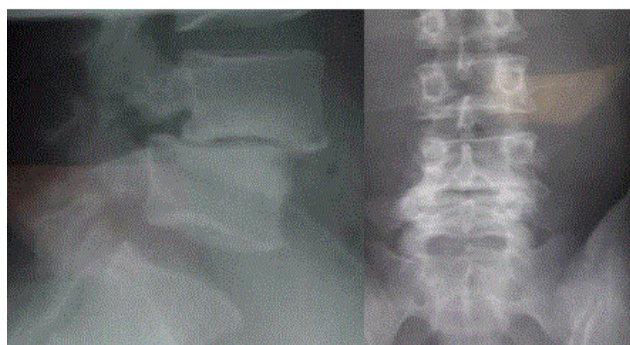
a. Lateral radiograph showing Myerding Grade 2 isthmic spondylolisthesis at L4-5, b. AP radiograph showing disc narrowing and collapse at L4-5.
